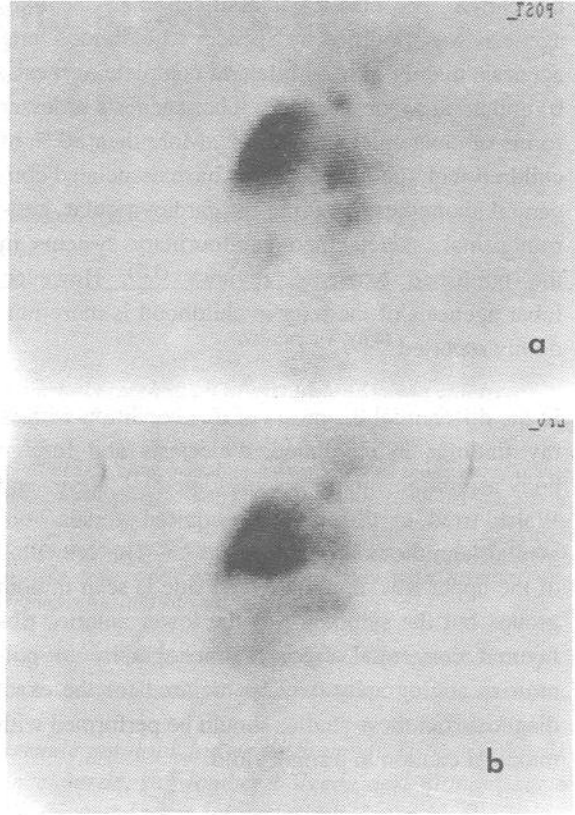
Pulmonary perfusion scintigraphy of the patient after bronchoscopy showing no perfusion in the left upper hemithorax. a) oblique view, b) posterior view.
